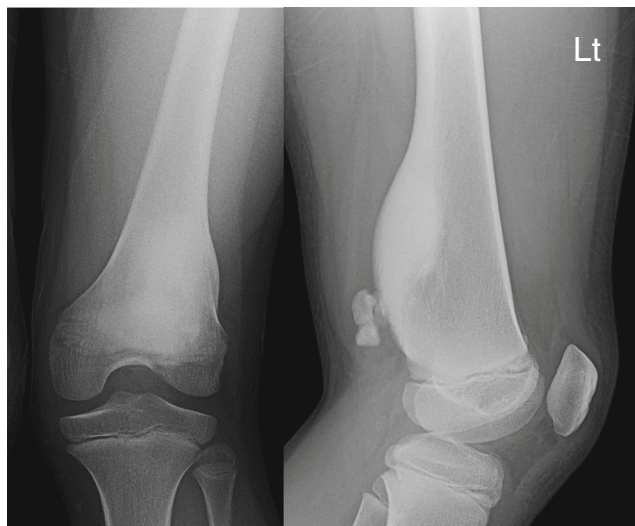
Plain radiography showed a lesion with homogeneous dense ossification in the posterior bone cortex from the distal diaphysis to the metaphysis of the femur. The margins of the lesion were smooth, and the lesion gradually thickened as it approached the center. No periosteal reaction was evident. Extracortical nodular lesions with calcification were also observed posteroinferior to the cortical lesion, but the continuity of calcification between the lesions was not apparent
